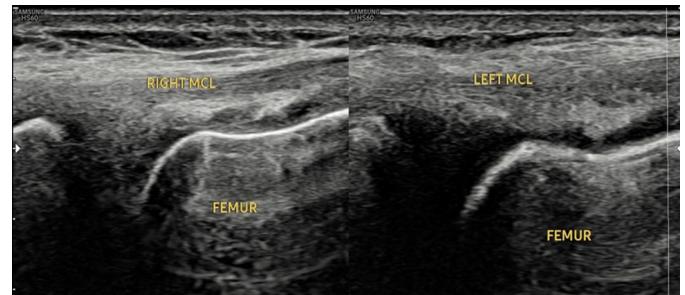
Ultrasound finding of thickened left MCL compared to the normal right MCL.
